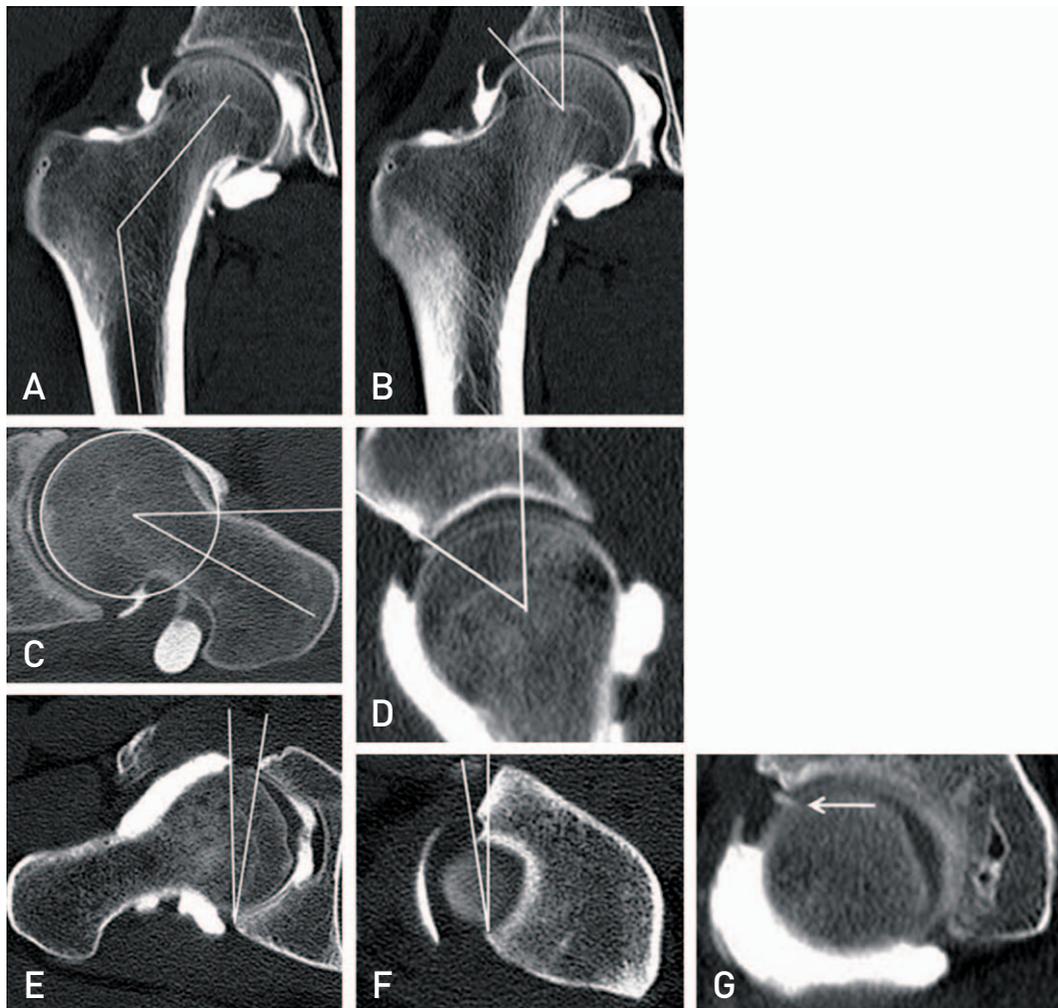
Assessment parameters with using multi-detector computed tomography arthrography. (A) Neck shaft angle, (B) lateral center edge angle, (C) alpha angle, (D) anterior center edge angle, (E) central acetabular version, (F) cranial acetabular version, and (G) labral abnormality (arrow).
